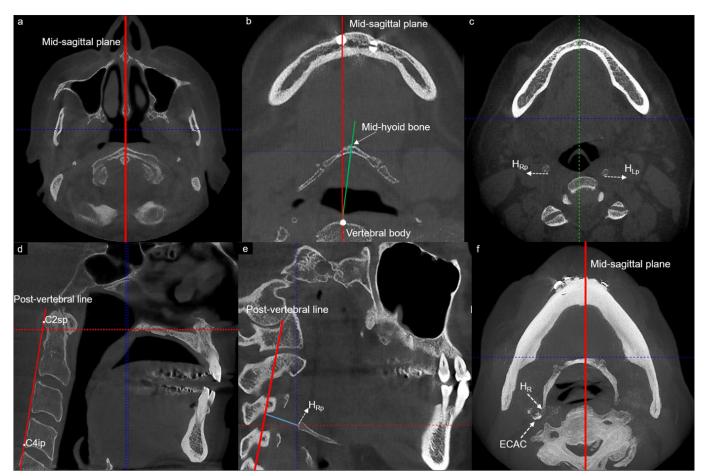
Axial cone-beam computed tomography (CBCT) images depicting mid-sagittal plane (a), assessment of posterior tilting of hyoid bone (b), and most posterior points of the hyoid bone left greater horn (HLp) and the right greater horn (HRp). Sagittal CBCT images showing post-vertebral line (C2sp – C4ip) (d) and the perpendicular distance from the most posterior point of the hyoid bone right greater horn (HRp) to the post-vertebral line (e). Maximum Intensity Projection (MIP) axial view (f) showing extra-cranial carotid artery calcification (ECAC) (17), hyoid bone right greater horn (HR), and the posterior tilting of the hyoid bone on right side in reference to mid-sagittal plane.
